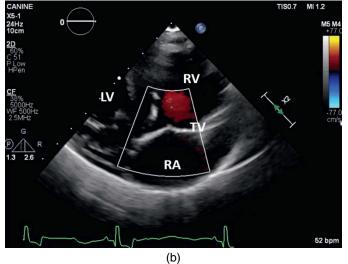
Images of the right auricle from the left cranial location show tricuspid valve leaflets opening upward into the right ventricle. This is ideal for diagnostic color as it aligns well with Doppler sound beams. (a) Flow through the valve during diastole is red and non-aliased. (b) During systole the lack of blue color on the atrial side of the valve is consistent with the absence of a leak.
